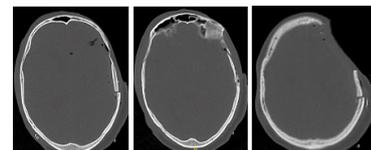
Post-operative CT with good alignment of the bone flap. On the far right, the bony defect through which the dura was adhered to is demonstrated.
